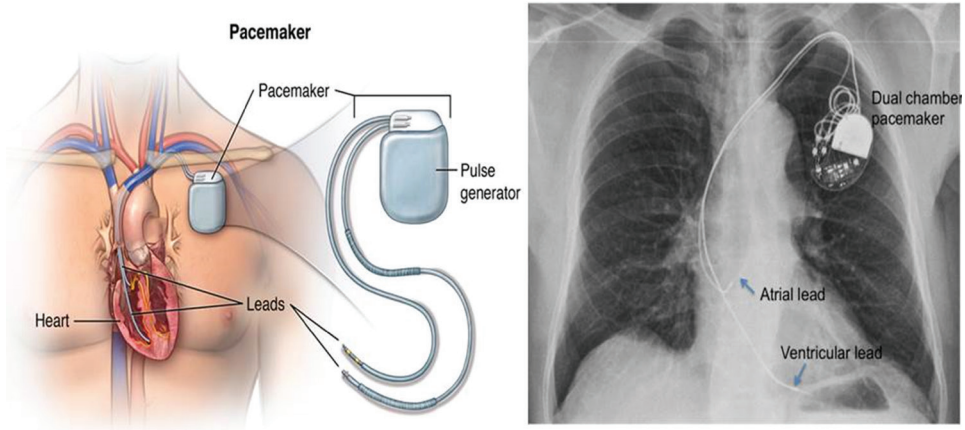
Demonstration of standard dual chamber pacemaker design and chest X-ray showing lead placement
